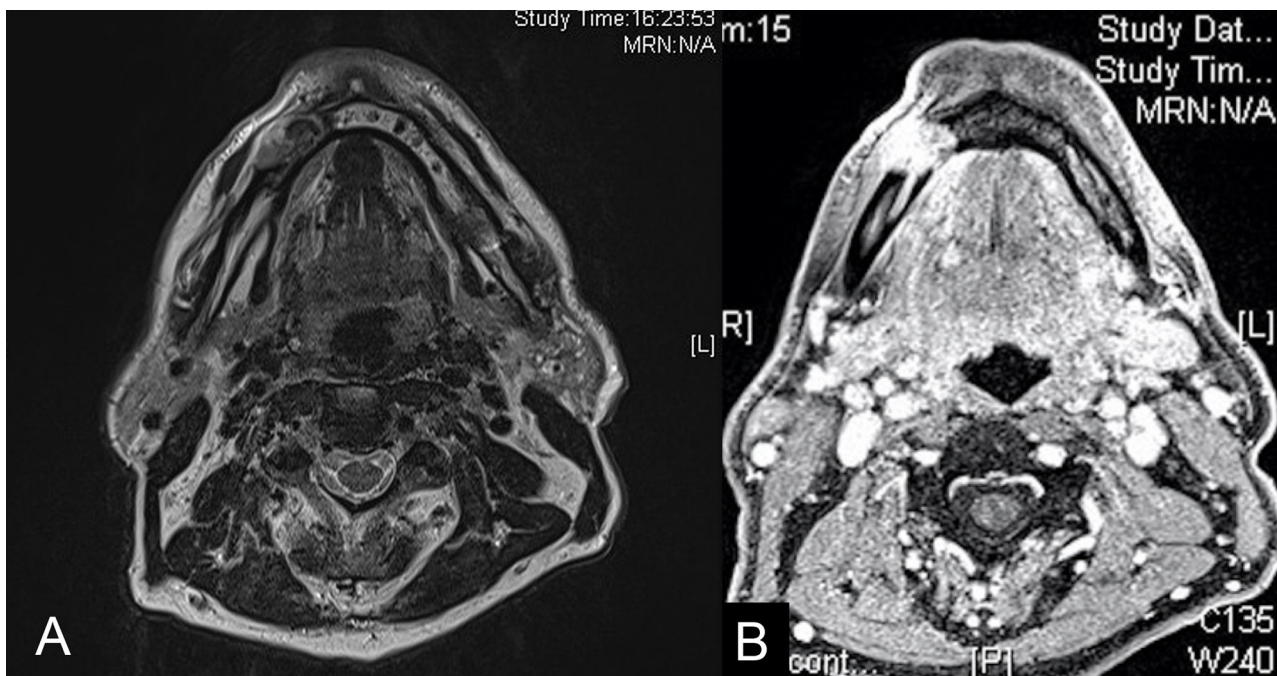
MRI of CCOC (axial view). A. T1 weighted image showing soft tissues invasion by the tumor. B. T2 weighted image showing mandibular nerve invasion by the tumor.
